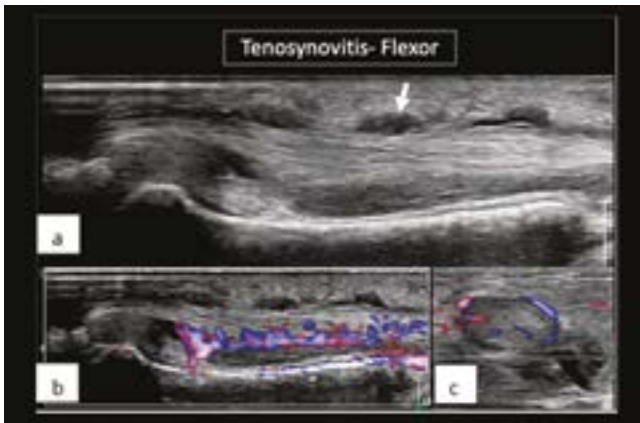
Tenosynovitis – Longitudinal grey scale image (a) shows thickening of the flexor tendon sheath of middle finger (arrow) which shows a power doppler signal in longitudinal (b) and short axis (c) views, suggesting inflammation
